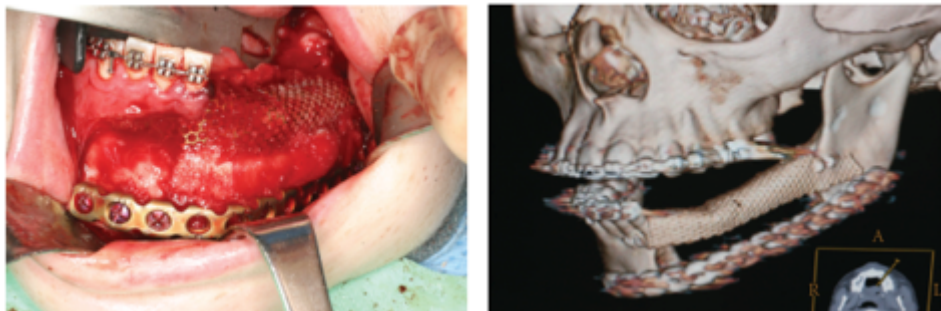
Reconstruction plate of the left body of the mandible with bioimplant, rhBMP-2/ACS, demineralised bone allograft and titanium mesh on the top on the left. On the right, the postoperative CT scan. (49)
